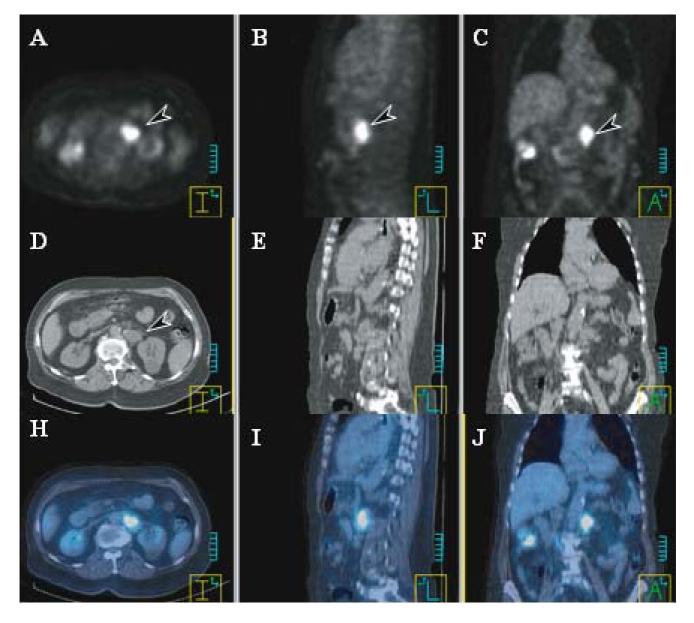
An 83-year-old woman with a history of colon cancer and a rising CEA underwent a combined PET/CT scan for staging. (A) transaxial, (B) sagittal and (C) coronal images show a focal area of abnormal [<sup>18</sup>F]-FDG uptake (arrow), corresponding to a retroperitoneal lymph node region on corresponding CT slices [(D), (E) and (F)]. Co-registered [<sup>18</sup>F]-FDG PET/CT images [(G), (H) and (I)] show precise localisation of the recurrent colon cancer in the retroperitoneum.
